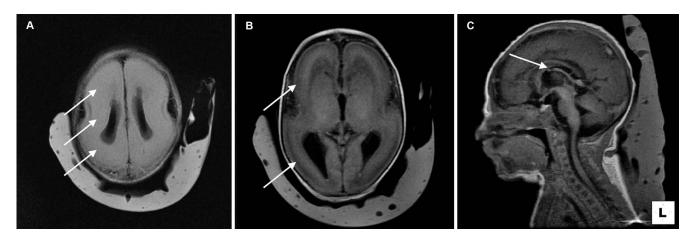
A: Magnetic resonance imaging shows overall immature sulcation pattern (arrows) B: with thickening of the cortex (arrows) compatible with lissencephaly that is generalized throughout the brain with some more normal-appearing cortex and sulci occurring in the medial occipital lobes as seen on the sagittal T1 sequence. C: Corpus callosum is small and thin (arrow).
